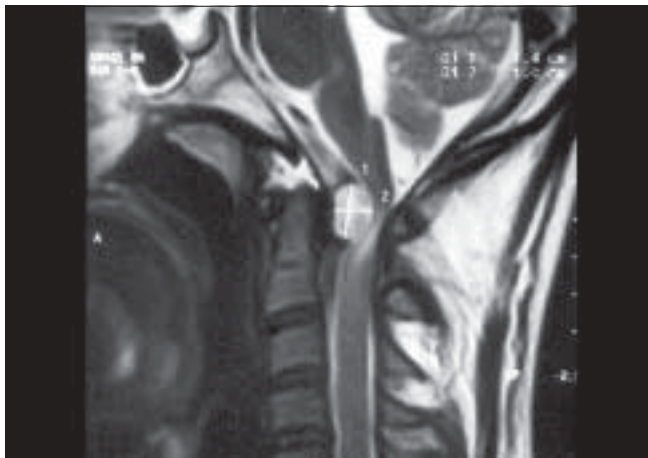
T2 weighted sagittal section of MRI showing anteriorly placed hyperintense tumor compressing the cord posteriorly with signal changes in the cord of same patient as of Figure 1
